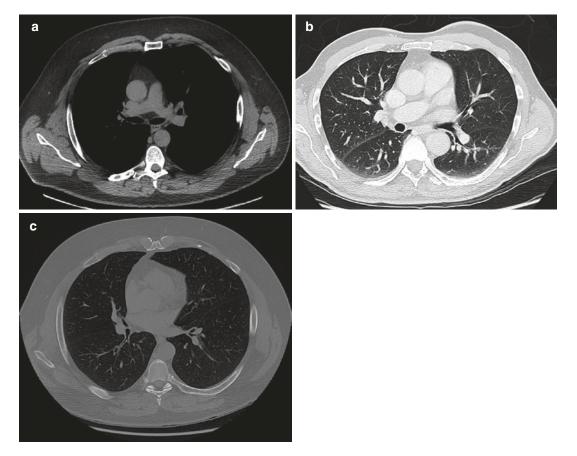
CT windows; the same image can be manipulated by changing window width and level to optimize structure of concern, (a) soft tissue/mediastinal windows, (b) lung windows, (c) bone windows
